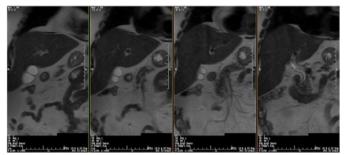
Coronal T2- weighted MRI image shows common bile duct, two different fundus and corpus.
